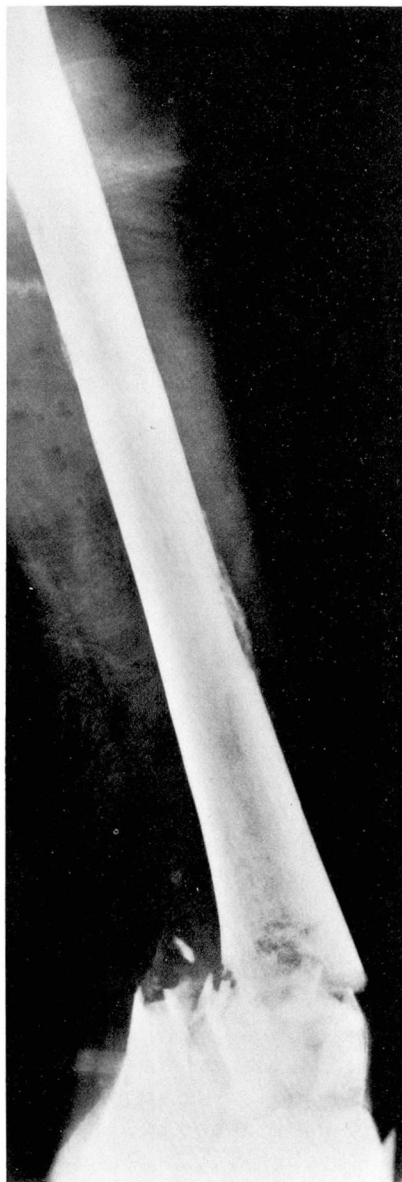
Roentgenogram taken later in clinical course shows area of cortical destruction and periosteal reaction in the diaphysis of femur laterally and medially.
